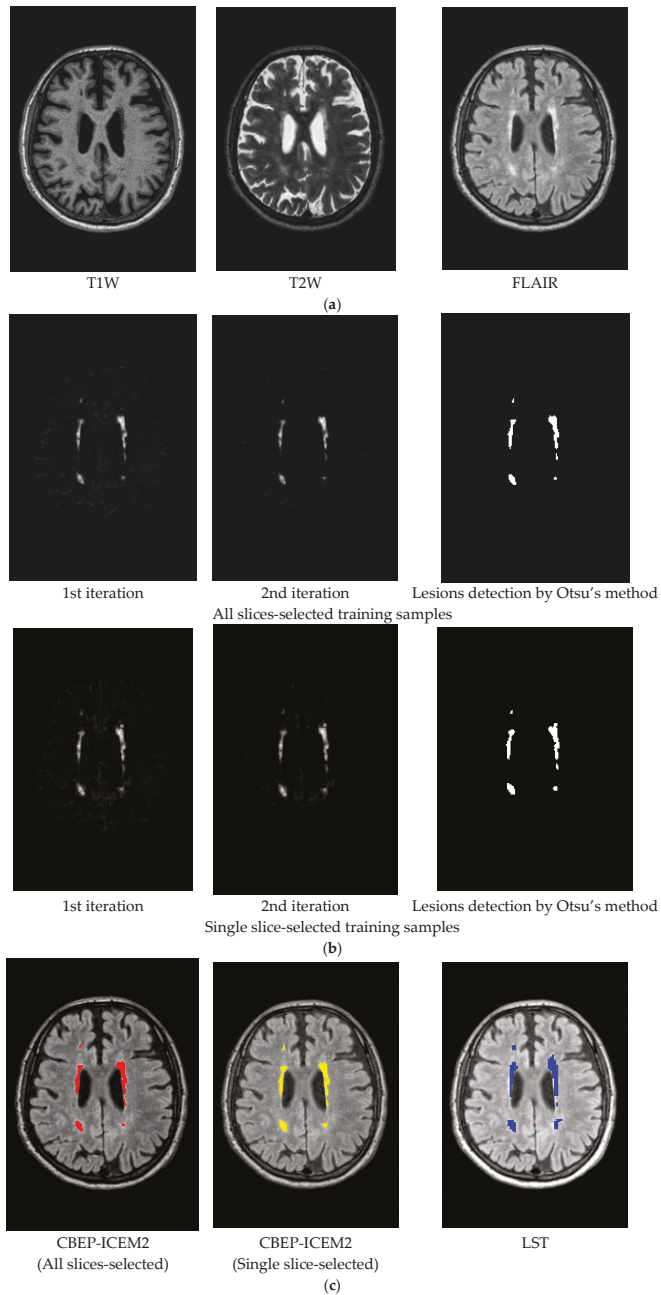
Lesion detection of Fazekas grade 1 by CBEP-ICEM2 and LST (a) Original MR images (T1W, T2W, FLAIR) with lesions of Fazekas grade 1; (b) CBEP-ICEM2-detected lesion of Fazekas grade 1; (c) Comparison between lesion detections by CBEP-ICEM2 and LST.
